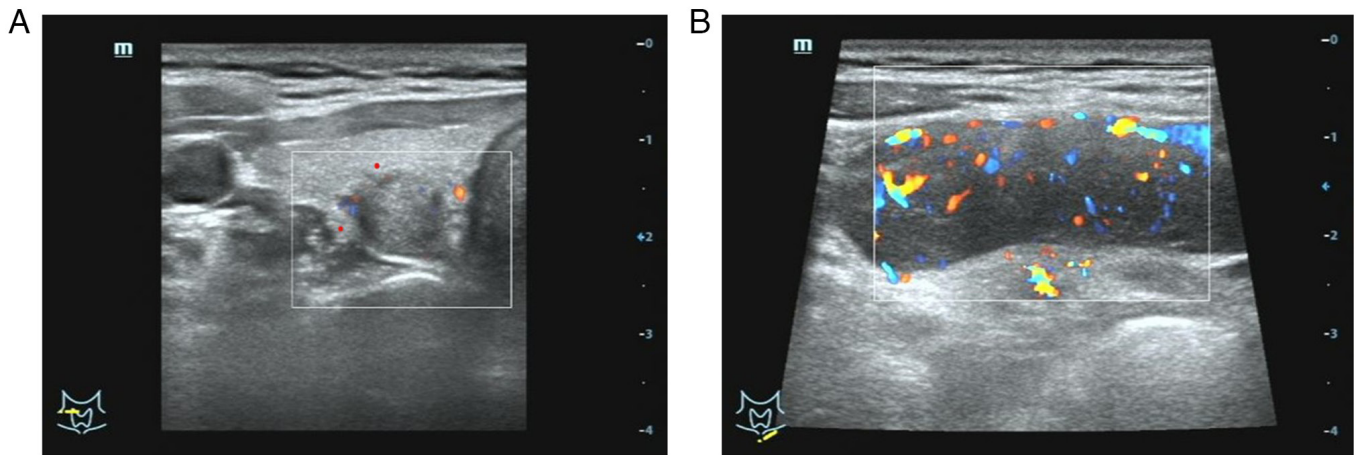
Preoperative ultrasound Doppler thyroid examination in October 2023. (A) hypoechoic nodules in the right thyroid gland. (B) An abnormal lymph node in the left supraclavicular fossa.
